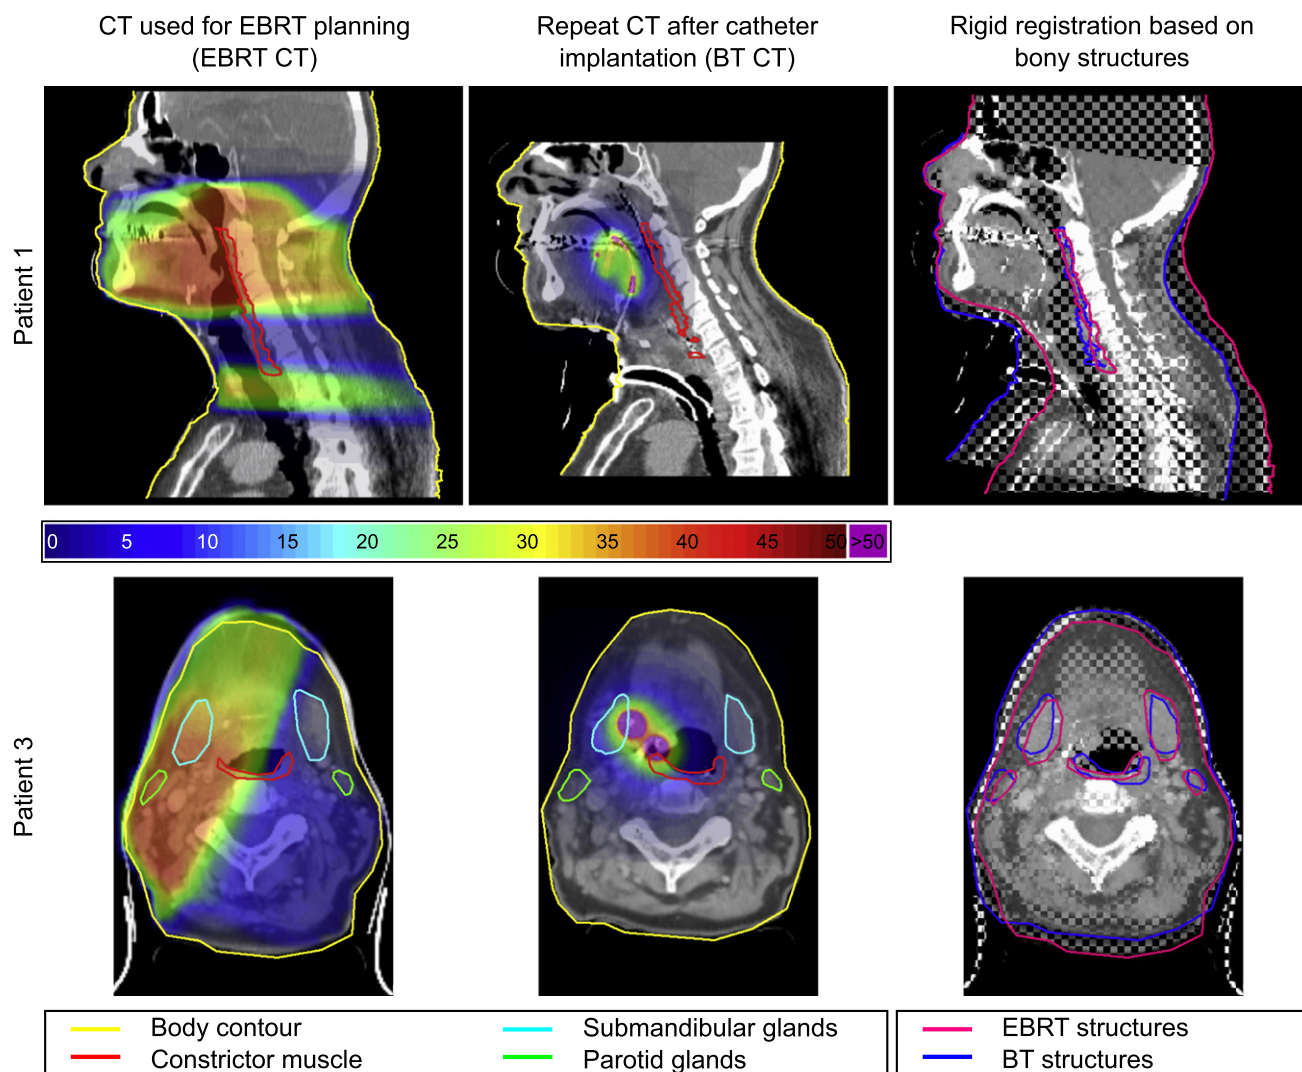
Anatomic changes between external beam radiotherapy (EBRT) and brachytherapy (BT) for 2 patients. First row, sagittal planes of Patient 1. Notice the large anatomic changes between the EBRT and BT computed tomography (CT) scan, mostly caused by neck dissection, catheter insertion, and different patient positioning. Second row, axial planes of Patient 3. Notice that rigid registration (last column) is not adequate to align both CT scans.
